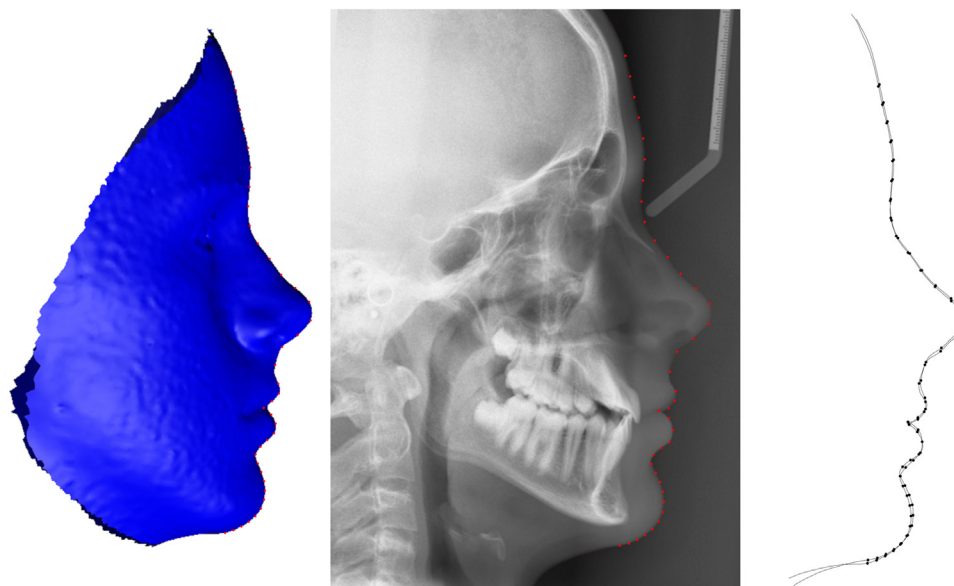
Example of 2 profile lines from the same patient, 1 draw on the true profile derived from the 3D photograph (*left*), 1 draw on the lateral cephalometric radiograph (*middle*; machine 2), and after Procrustes best-fit superimposition (*right*).
